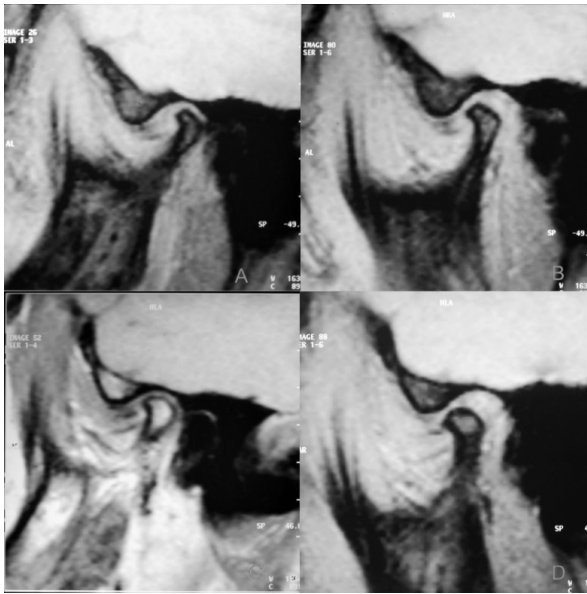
MRI of TMJ (A: Right - Open B: Right - Close C: Left - Closed D: Left - Open)
